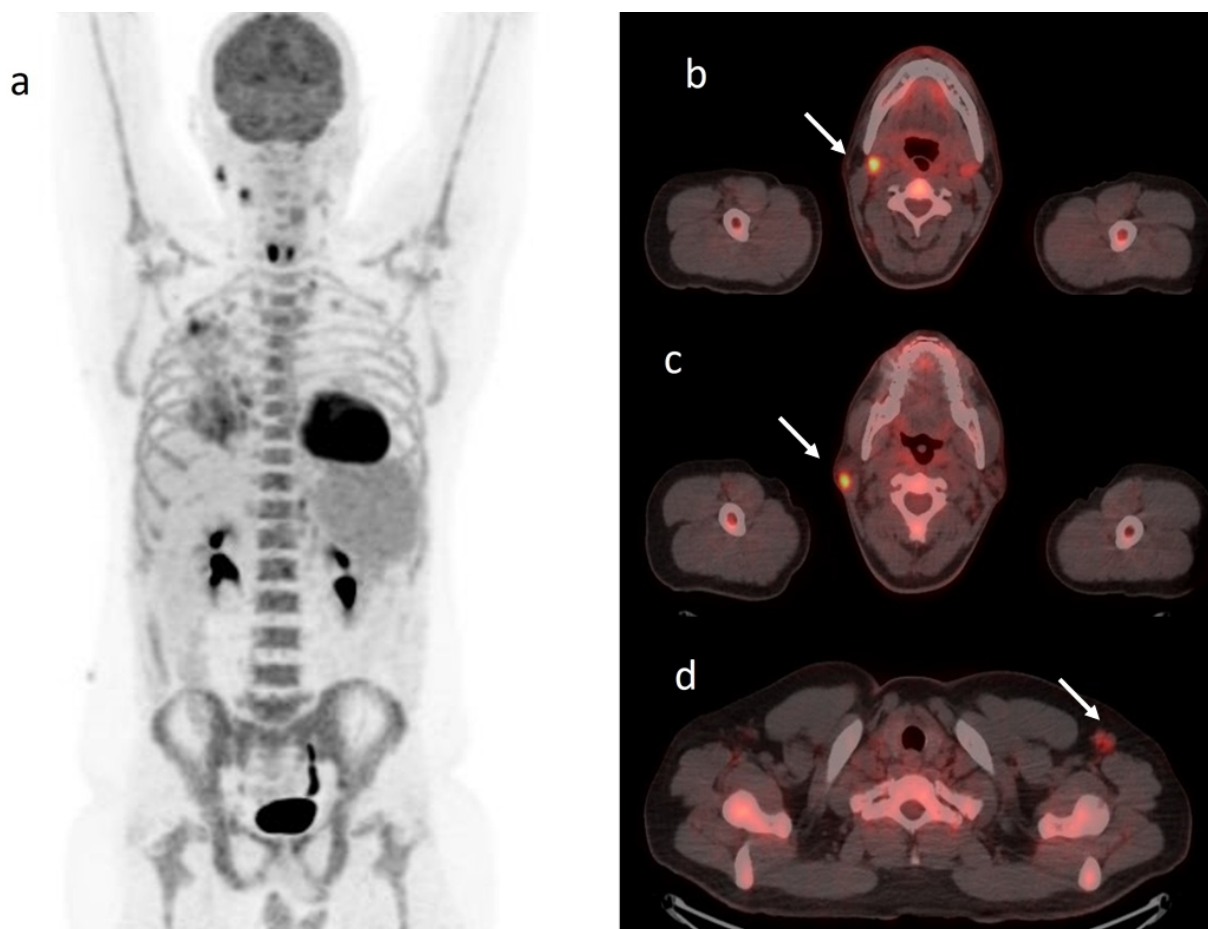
Maximum intensity projection (MIP) image of ^{18}F -FDG PET (a) and fused ^{18}F -FDG PET/CT images showing hypermetabolic cervical (b and c) and axillary (d) lymph nodes (white arrows).
